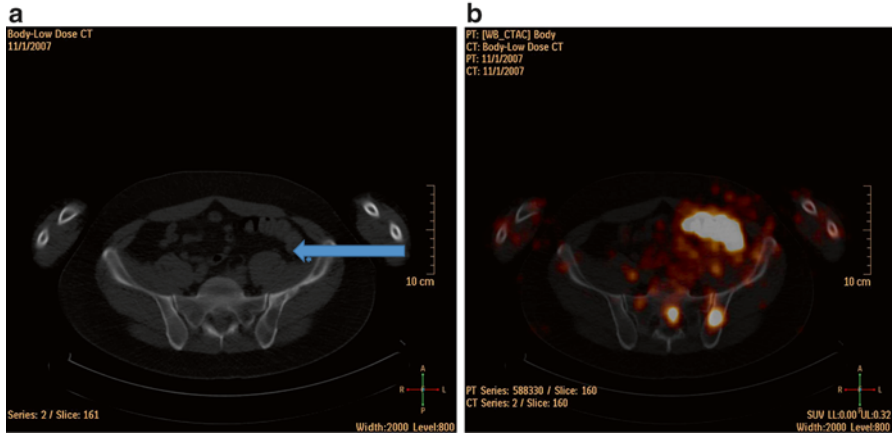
(a) Computerized tomographic scan of pelvis indicating that the focus positive on PET scan was located in the *left* pelvic bone (*arrow*). (b) Fusion of the transverse CT image of the pelvis with the corresponding transverse iodine-124 PET image demonstrating localization of the lesion. The fused images demonstrated that the abnormal iodine-124 uptake corresponded precisely to the abnormality on the CT scan. In addition to localizing this abnormality, the 124I images demonstrated a second focus of abnormal iodine-124 uptake that correlated with another abnormality in the sacrum on the CT image suggesting an additional metastasis
